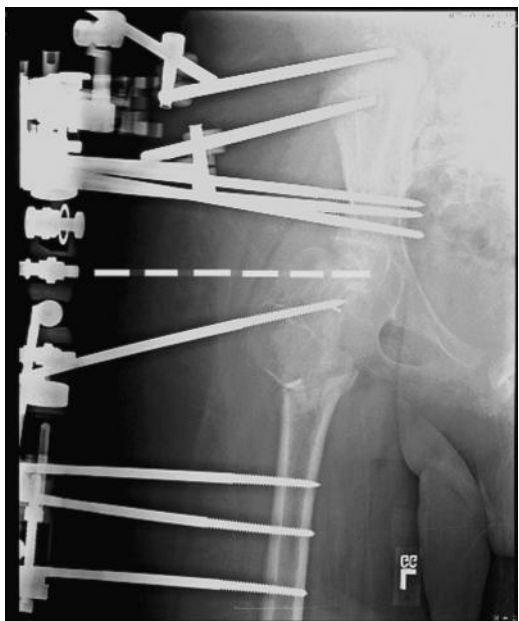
A, AP pelvis x-ray demonstrating appropriate alignment of the femoral head center of rotation.
